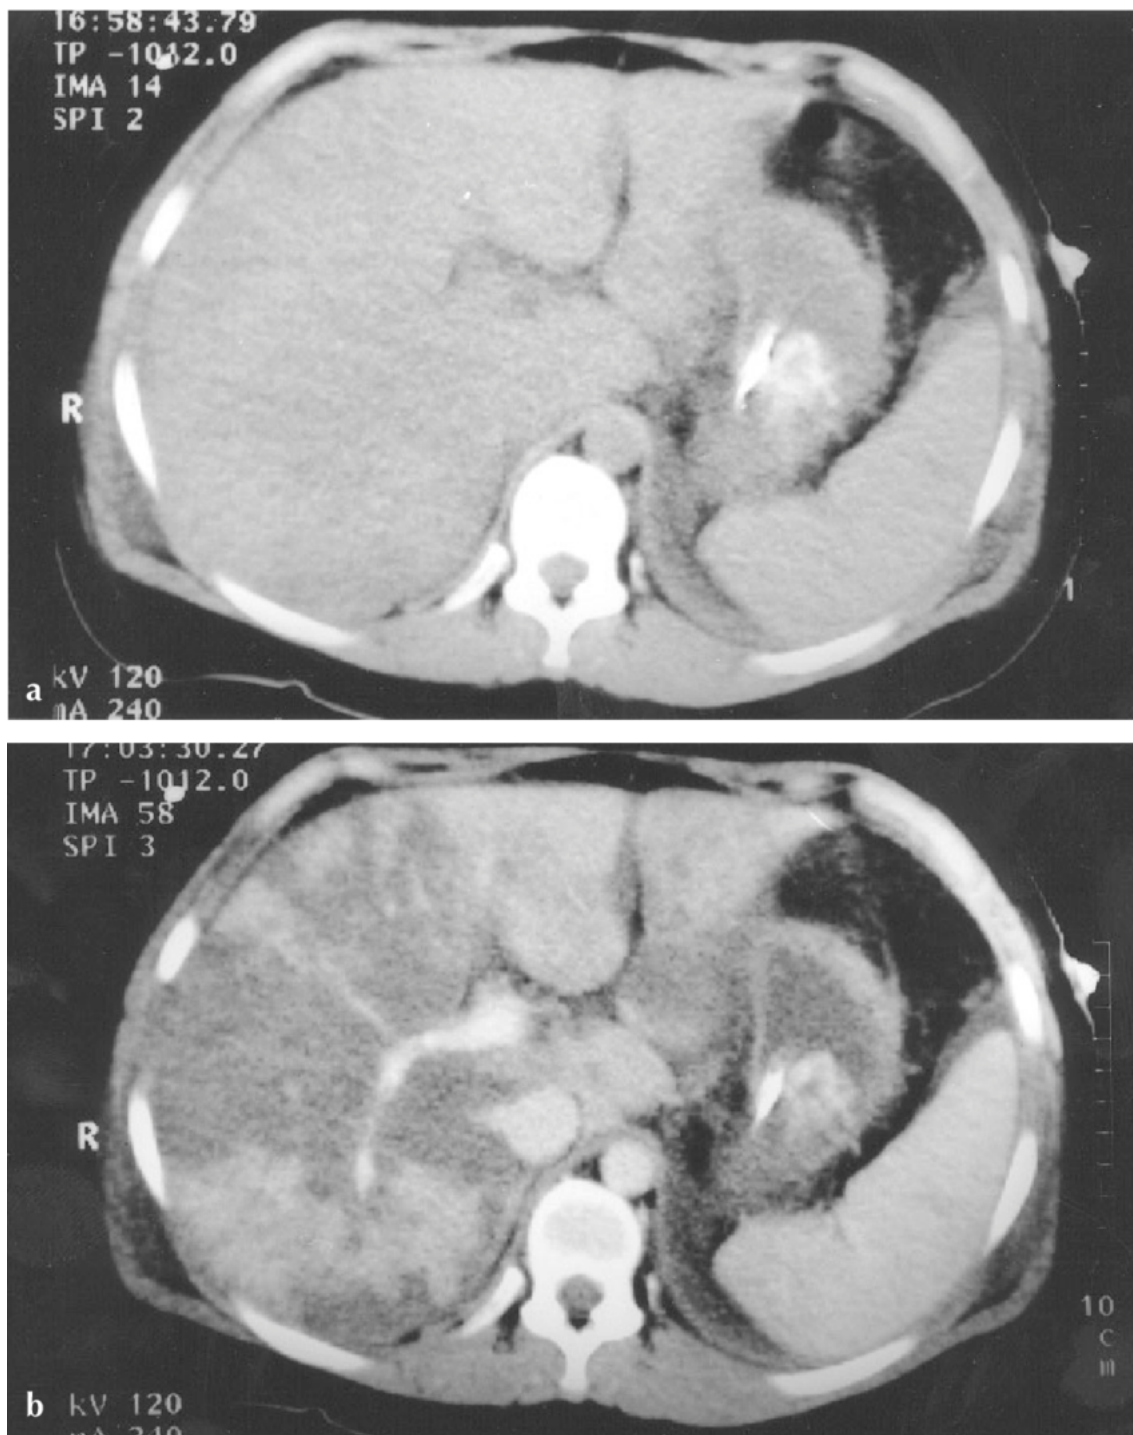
Pre (a) and post (b) contrast CT images of a woman with pre-eclampsia
